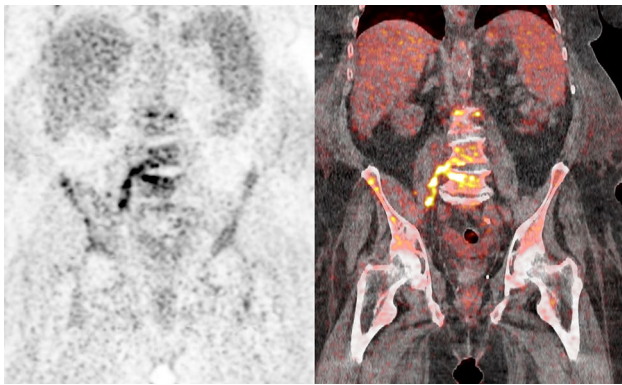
Spondylodiscitis with unilateral paravertebral extension. A 61-year old man with back pain, fever and sepsis. His medical history includes alcohol abuse and Child–Pugh B liver cirrhosis. Blood culture was positive for *Streptococcus anginosus*. Portal of entry was either a recent dental extraction or a skin wound at the lateral malleolus. [¹⁸F]FDG PET/CT shows increased uptake in the L4 and L5 endplates at the right lateral side, extending into the paravertebral soft tissues along the psoas muscle (coronal PET and fused PET/CT images at left and right panels), suggestive of spondylodiscitis. No MRI was performed because the abdominal circumference did not fit into the MRI gantry
